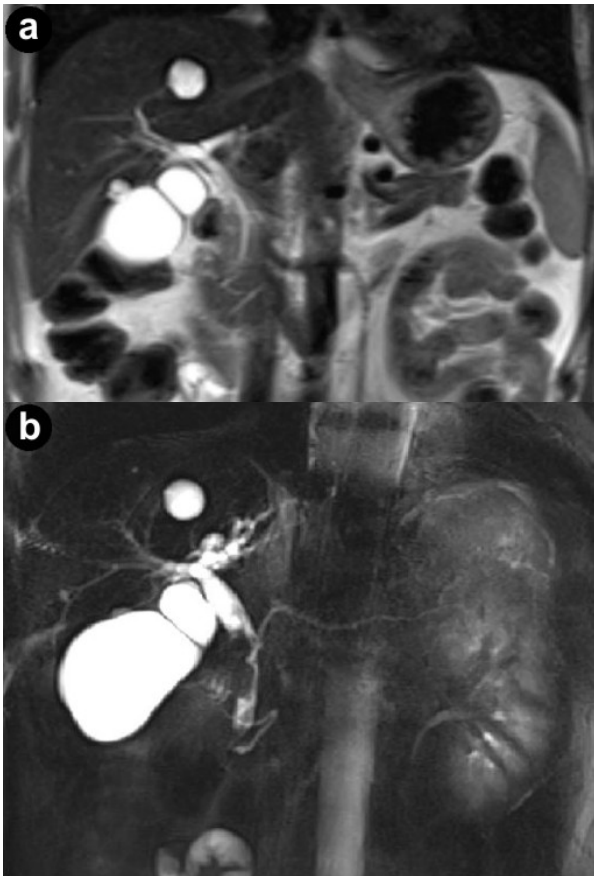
Conventional turbo spin echo T2-weighted coronal (a.) and cholangiopancreatography (b.) magnetic resonance sequences. MR views show a lengthy stricture with abrupt and asymmetric narrowing in the middle and lower third of the common bile duct; the proximal biliary tree is dilated.
